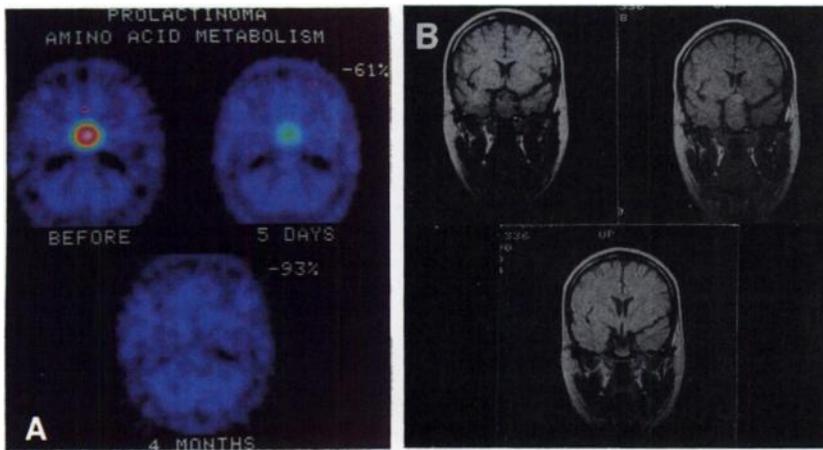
(A) A patient with prolactinoma was evaluated with ^{11}C -methionine. The initially very high metabolism in the tumor (upper left) is rapidly reduced when bromocriptine therapy is started (upper right). Within 3 mo, the tumor size is reduced to half its original size and the amino acid metabolism is reduced by 70%. The patient was referred again 1 mo later because of rapid expansion of the tumor, suggesting escape from response to medication. PET demonstrates (lower) lack of metabolism in the tumor thus excluding active tumor growth. (B) MRI performed 2 mo after start of treatment (upper left) showed reduced tumor size, whereas MRI at 4 mo after start of treatment (upper right) demonstrated a rapidly expanding tumor without signs of necrosis but a small bleeding that could not explain the great enlargement of the tumor. A 2-yr follow-up (lower) showed a marked regression of the tumor.
